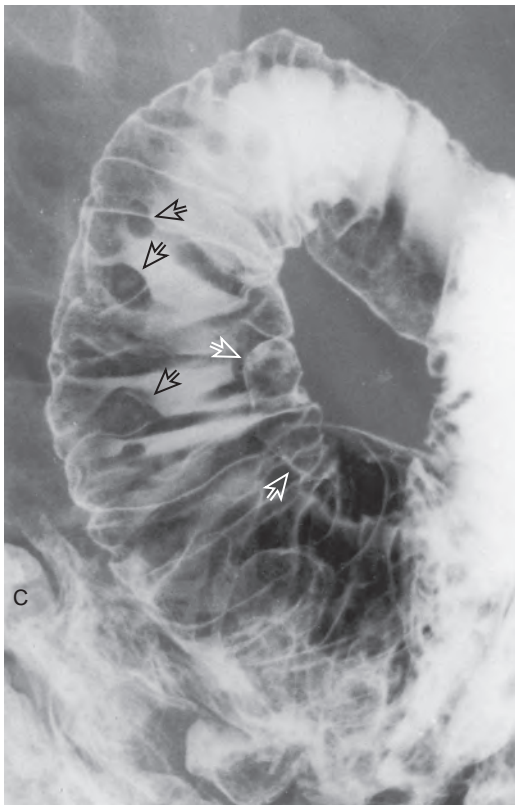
Air-contrast examination of duodenum after enteroclysis. Spot radiograph shows multiple small polyps (several identified by open black arrows) as radiolucent filling defects in the shallow barium pool on the posterior wall of the descending duodenum. The papilla of Vater is enlarged (open white arrows). Contrast in the colon (C) partly obscures the third portion of the duodenum. This patient had familial adenomatous polyposis syndrome. The polyps were tubular adenomas; the enlarged papilla of Vater resulted from an adenocarcinoma arising in a tubulovillous adenoma.
